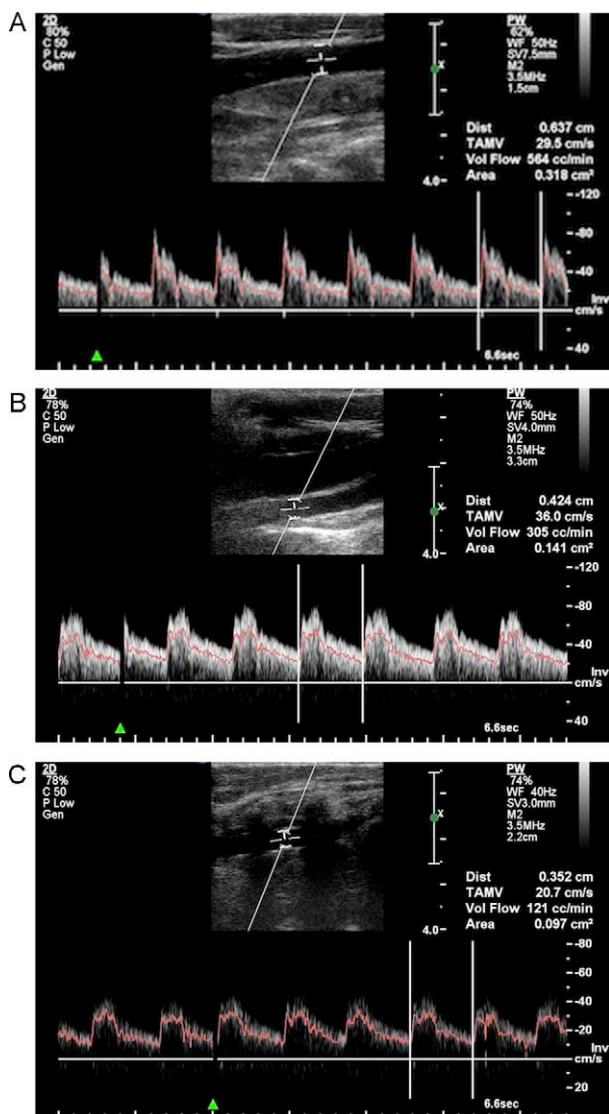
VFR measurements using Doppler method in CCA (A), ICA (B), and VA (C) with large sample volumes across the entire vessel lumens.
